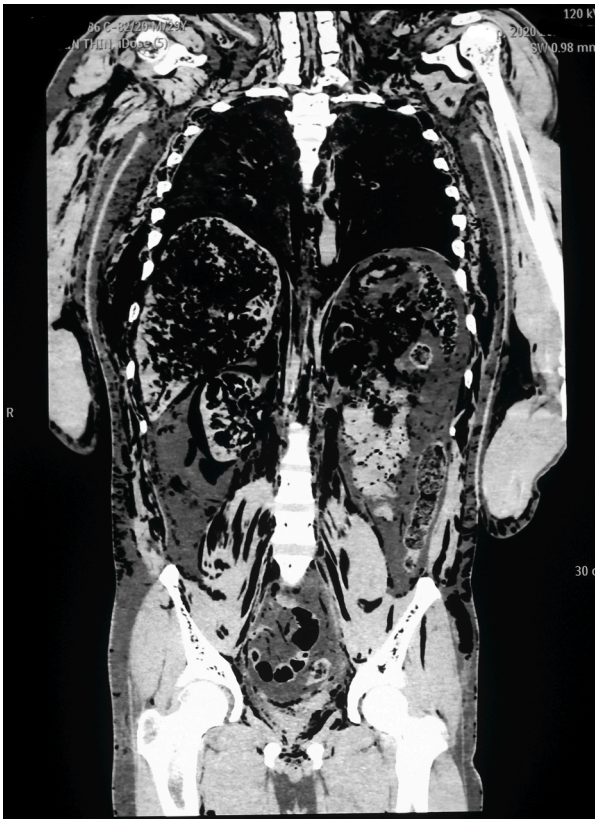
CT of the torso, coronal view: Post mortem decomposition gas in the form of diffuse subcutaneous emphysema. There is diffuse free air in subcutaneous, intramuscular, intraosseous, and intravisceral planes, including thorax and abdomen.
